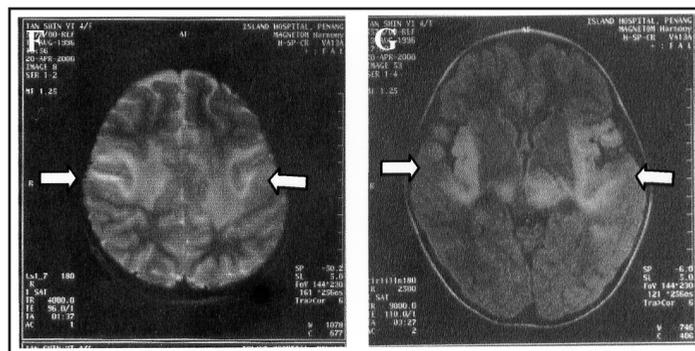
(Case 3): Magnetic resonance T2 weighted (F) and FLAIR (G) sequence axial images showing hyperintense signals in the white matter of both parietal and temporal lobes as well as in the basal ganglia (white arrows).
